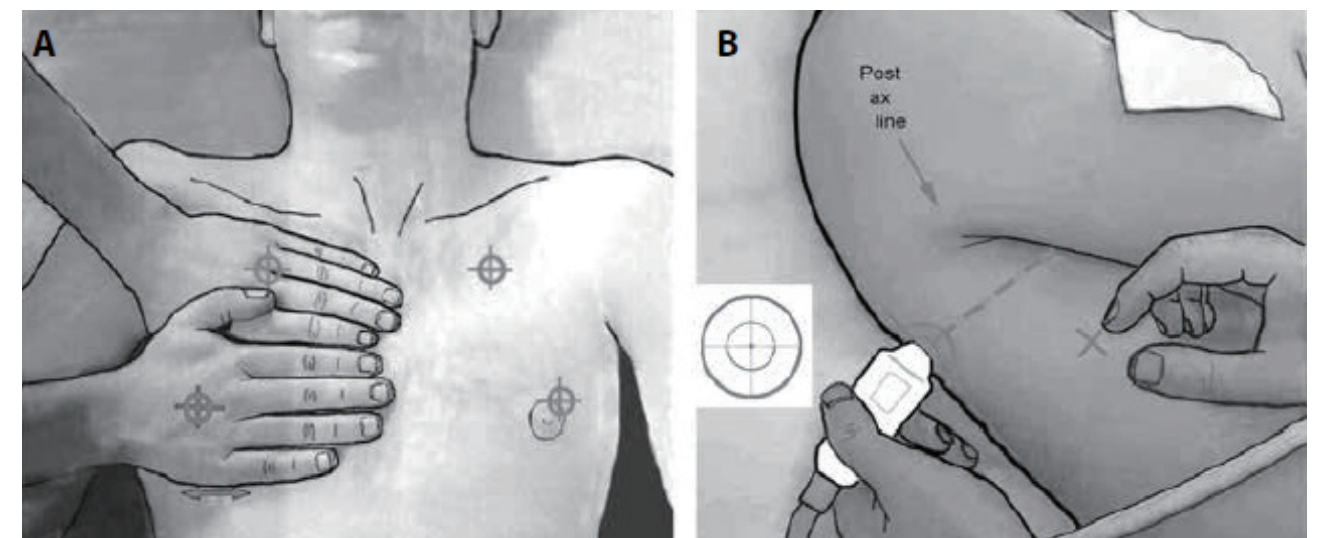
Areas of investigation showing the standardized examination lung ultrasound point; (A) Upper, lower anterior point. (B) Posterolateral alveolar or pleural syndrome (PLAPS) point.
